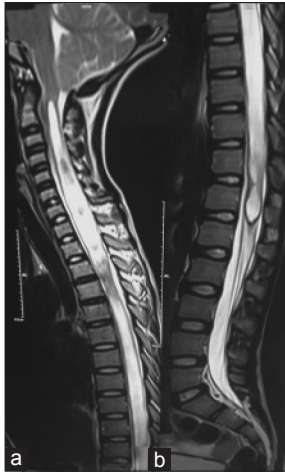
(a,b) Sagittal T2-weighted images show herniation of peg-shaped cerebellar tonsils 8 mm below the level of the foramen magnum with mild expansion of cervical spinal cord with hydrosyringomyelia and extension upto upper border of L1
